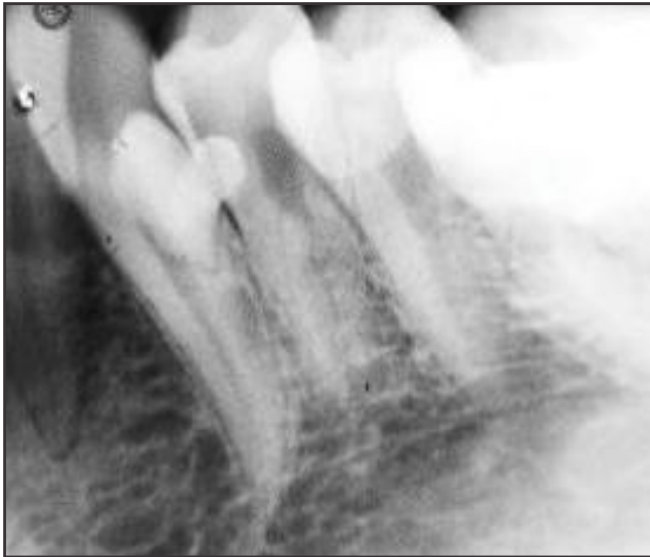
Intraoral periapical radiograph showing radiopaque tooth like single structure with radiolucent halo inside the opacity
